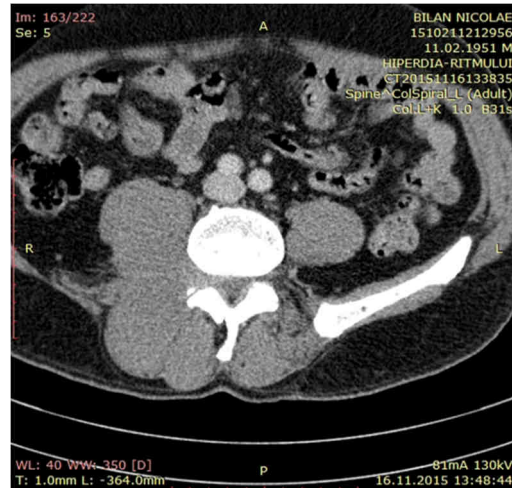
Axial CT image at the level of the L4 vertebra that shows swelling of the iliopsoas muscle and the right paraspinal muscles with post-contrast enhancement
